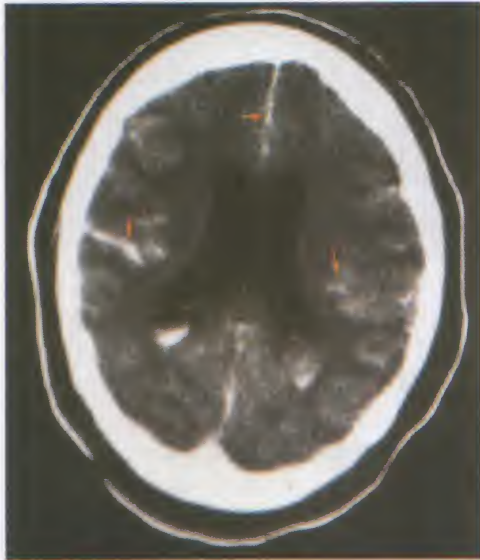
CT brain showing increased density in brain sulci denoting subarachnoid hemorrhage.
